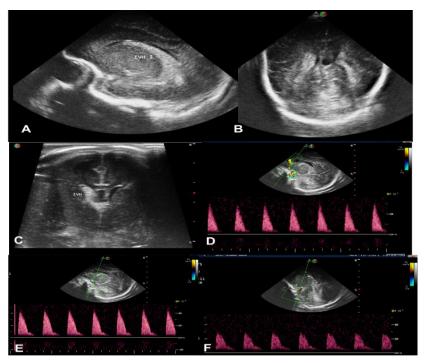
Doppler criteria (wave forms) include mean velocity [MV], pulsatility index [PI] and resistive index [RI]. These parameters were measured in internal carotid artery [ICA]; (A), middle cerebral artery [MCA]; (B) and anterior cerebral artery [ACA]; (C).
